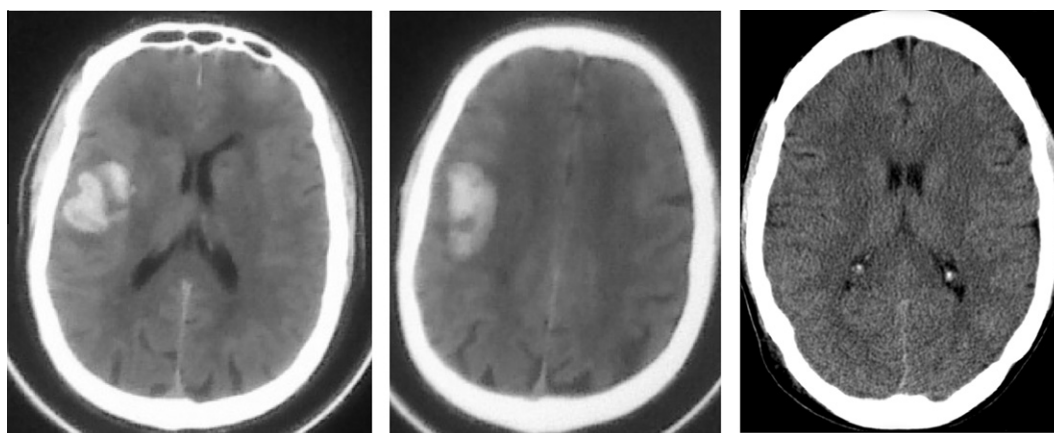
CT scan (axial view) showing right parietal ICH in a hemophilic patient aged 10 years. CT scan (axial view) showing resolution of ICH after two months of conservative treatment.
